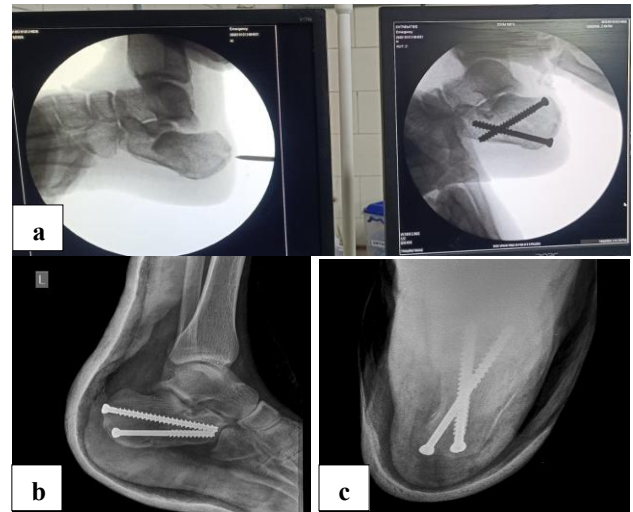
Radiographic tracking and hardware confirmation of cannulated cancellous screw fixation (a) intraoperative fluoroscopic screen captures demonstrating percutaneous reduction and optimal cross-screw alignment, (b) postoperative lateral radiograph at follow-up showing correction and maintenance of Böhler's and Gissane's angles, and (c) postoperative axial radiograph showing the hardware pathway and maintenance of horizontal heel width.
